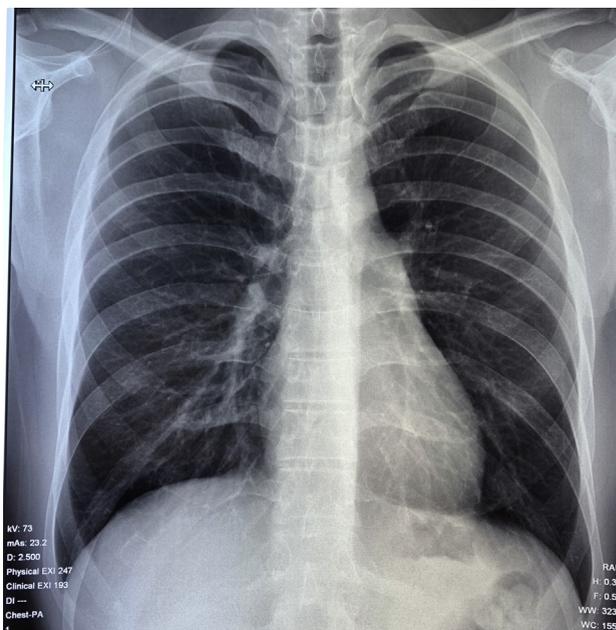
Chest x-ray after evacuation on Day 8.
